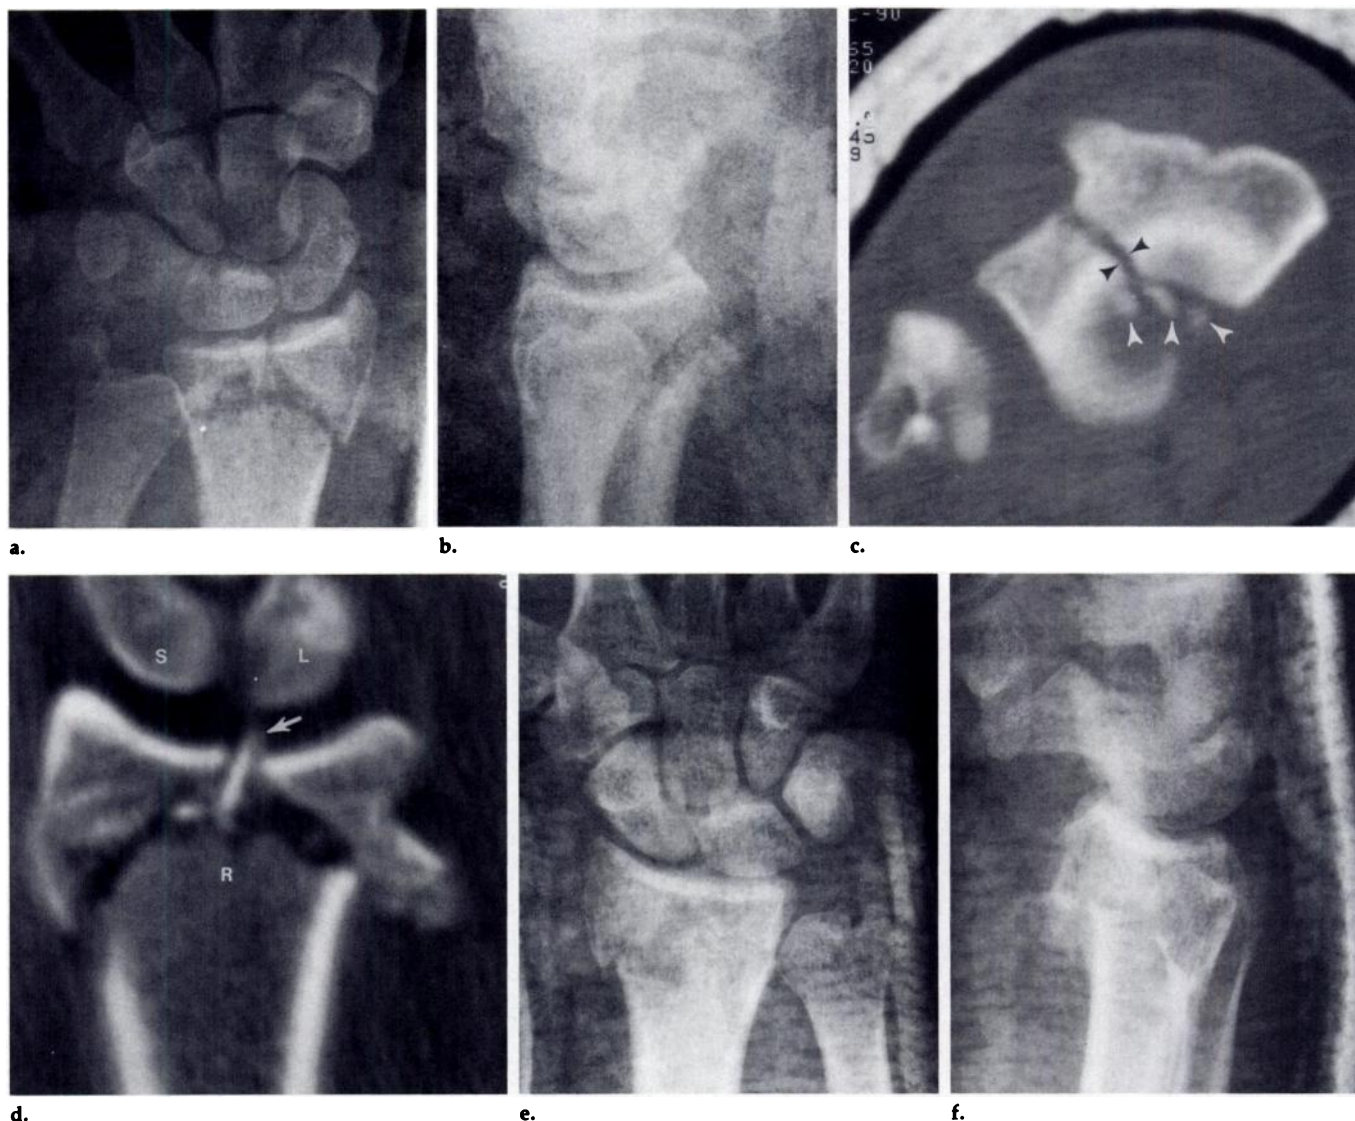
Distal radius fracture. (a) Posteroanterior view and (b) lateral view of the left wrist in a cast show comminuted distal radius and ulna styloid fractures. The distal articular surface of the radius in the lateral view is in a neutral position. (c) Axial image shows lunate fossa diastasis (between black arrowheads) and comminution (white arrowheads). (d) Sagittal image shows rotated fragment (arrow) projecting into radiolunate fossa with comminution and impaction of distal radius (R). Identification of this fragment changed the management of this case by indicating the need for an operation to remove the fragment from the joint space. L = lunate, S = scaphoid. (e) Posteroanterior and (f) lateral views of the right wrist in a cast show a comminuted distal radius fracture, with 10° dorsal inclination of the distal articular surface of the radius. (g) Sagittal image shows depression of a central fragment (arrow) in the lunate fossa of the radius not evident on routine radiographs (e, f). The palmar rim of the radius (white arrowhead) is displaced palmarly and rotated dorsally. The dorsal rim (black arrowhead) is displaced dorsally.
